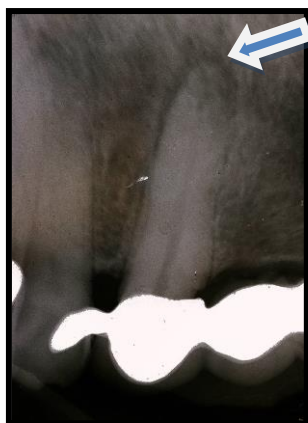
Traumatized tooth with periapical radiolucency
